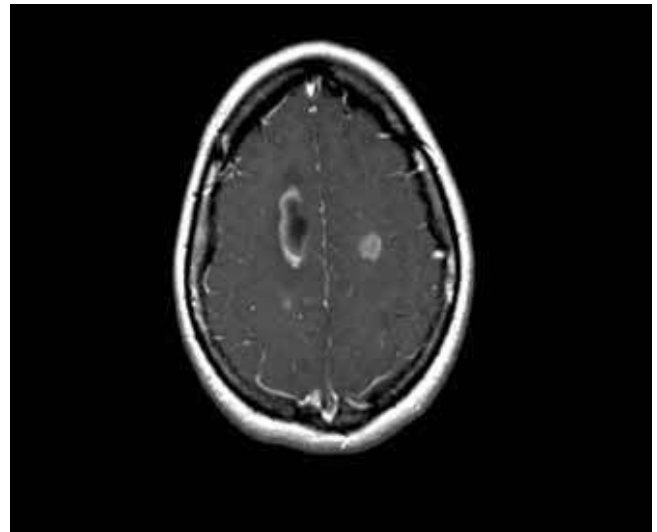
Case of MRI ADEM
